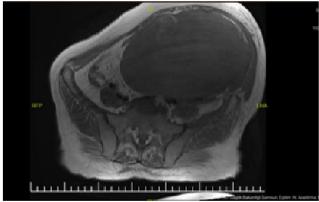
A mass of approximately 28 cm in diameter extending into the inguinal canal in the abdominal MR imaging of the patient.
